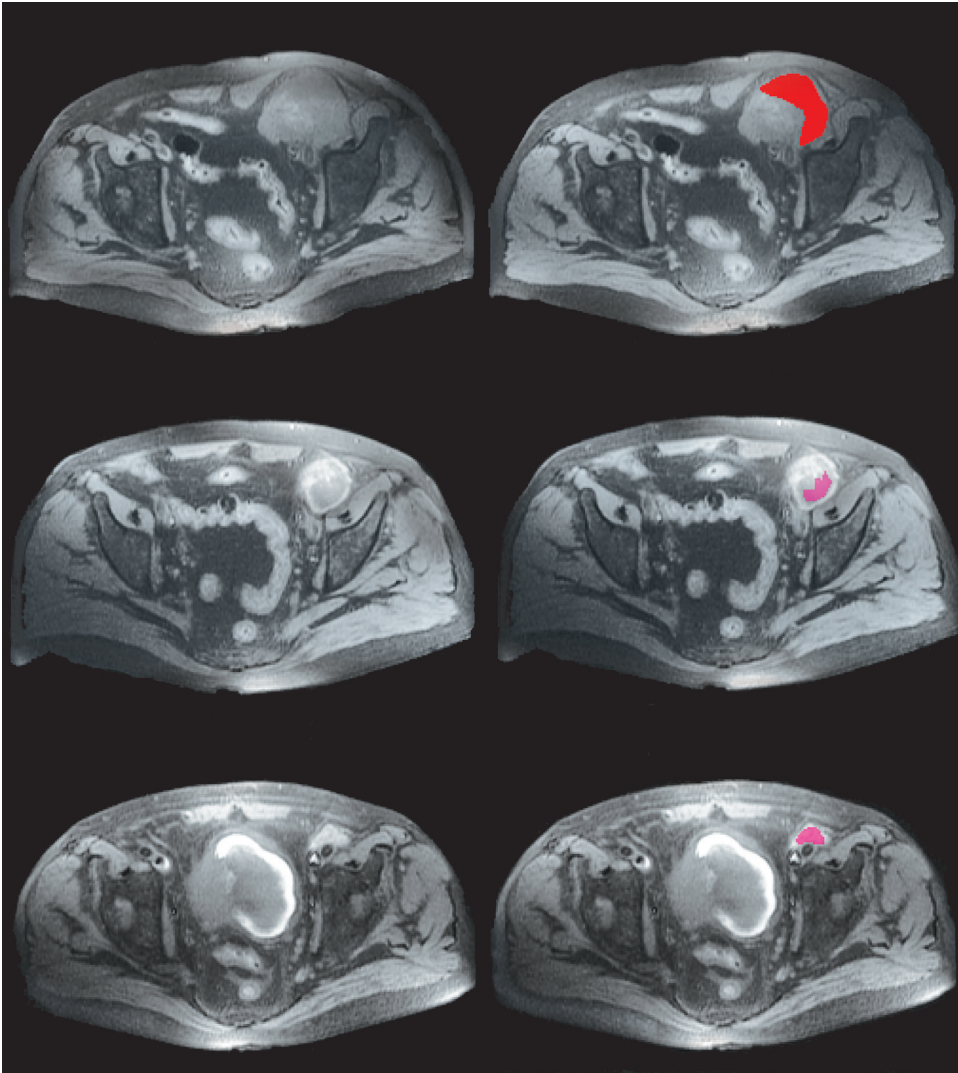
Axial T1-weighted SE fat saturation image slices of a typical subject (left), and ROIs drawn on a lymphoma mass (right). Images in the first row are from the diagnostic phase (examination 1), images in the second row are from examination 2, and images in the last row are from examination 3.
